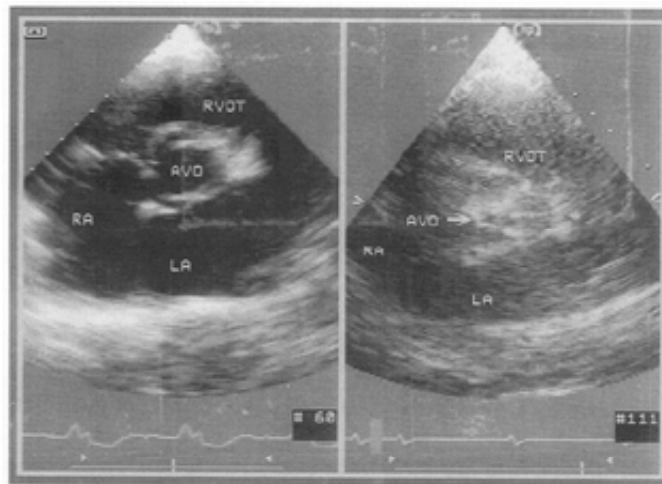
Two-dimensional echocardiography of the basal, parasternal, short-axis view in systole. The aortic valve opening (AVO) is easily visualized. Normal AVO (left) and severely reduced AVO (right) in a patient with aortic stenosis. RA = right atrium; LA = left atrium; RVOT = right ventricular outflow tract.
